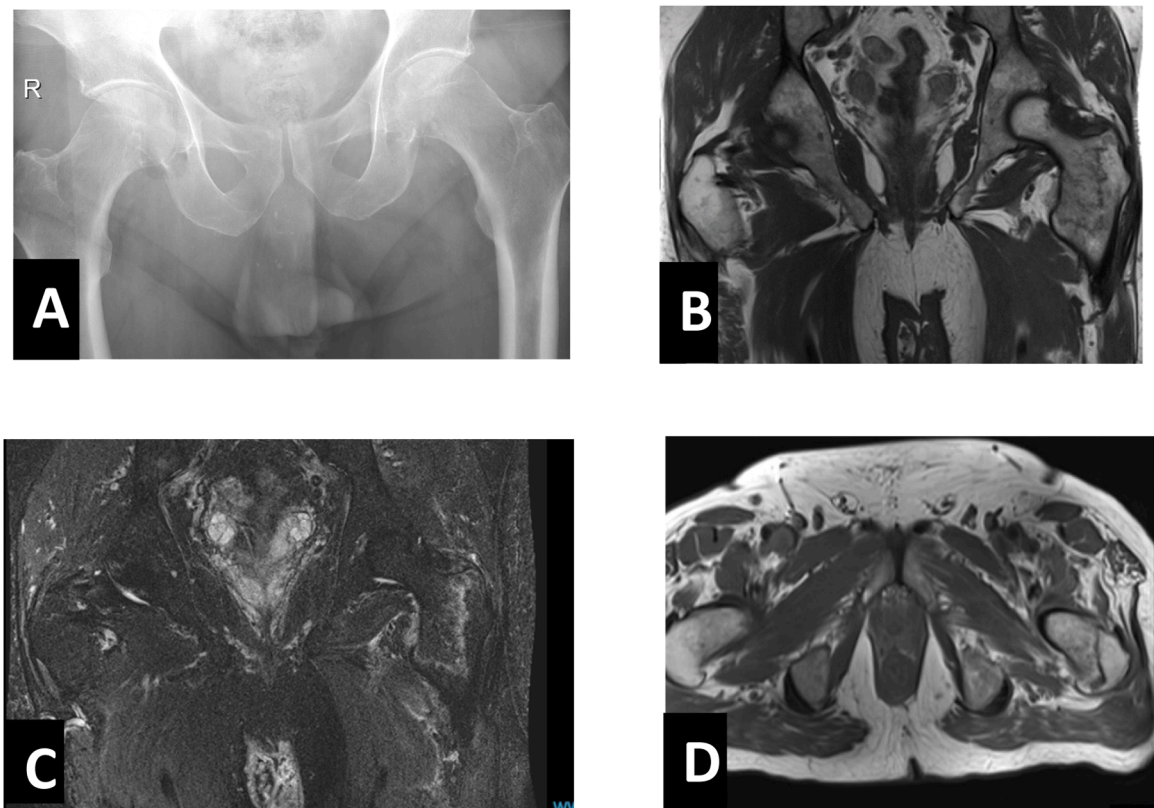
(A–D) Images of 79 years male sustaining a fall on his left side. No findings on plain radiographs, MRI was conducted as part of our diagnostic protocol due to clinical suspicion of occult fracture. Fig. A- Plain pelvic radiograph no fracture was diagnosed Fig. B- Coronal T1 sequences MRI image, showing a fracture line with low signal in the intertrochanteric region. Fig. C- Mid Coronal T2 sequences MRI image, showing the fracture line. Fig. D- Axial plane T1 sequences MRI image, showing a line with low signal extending to the anterior cortex.
